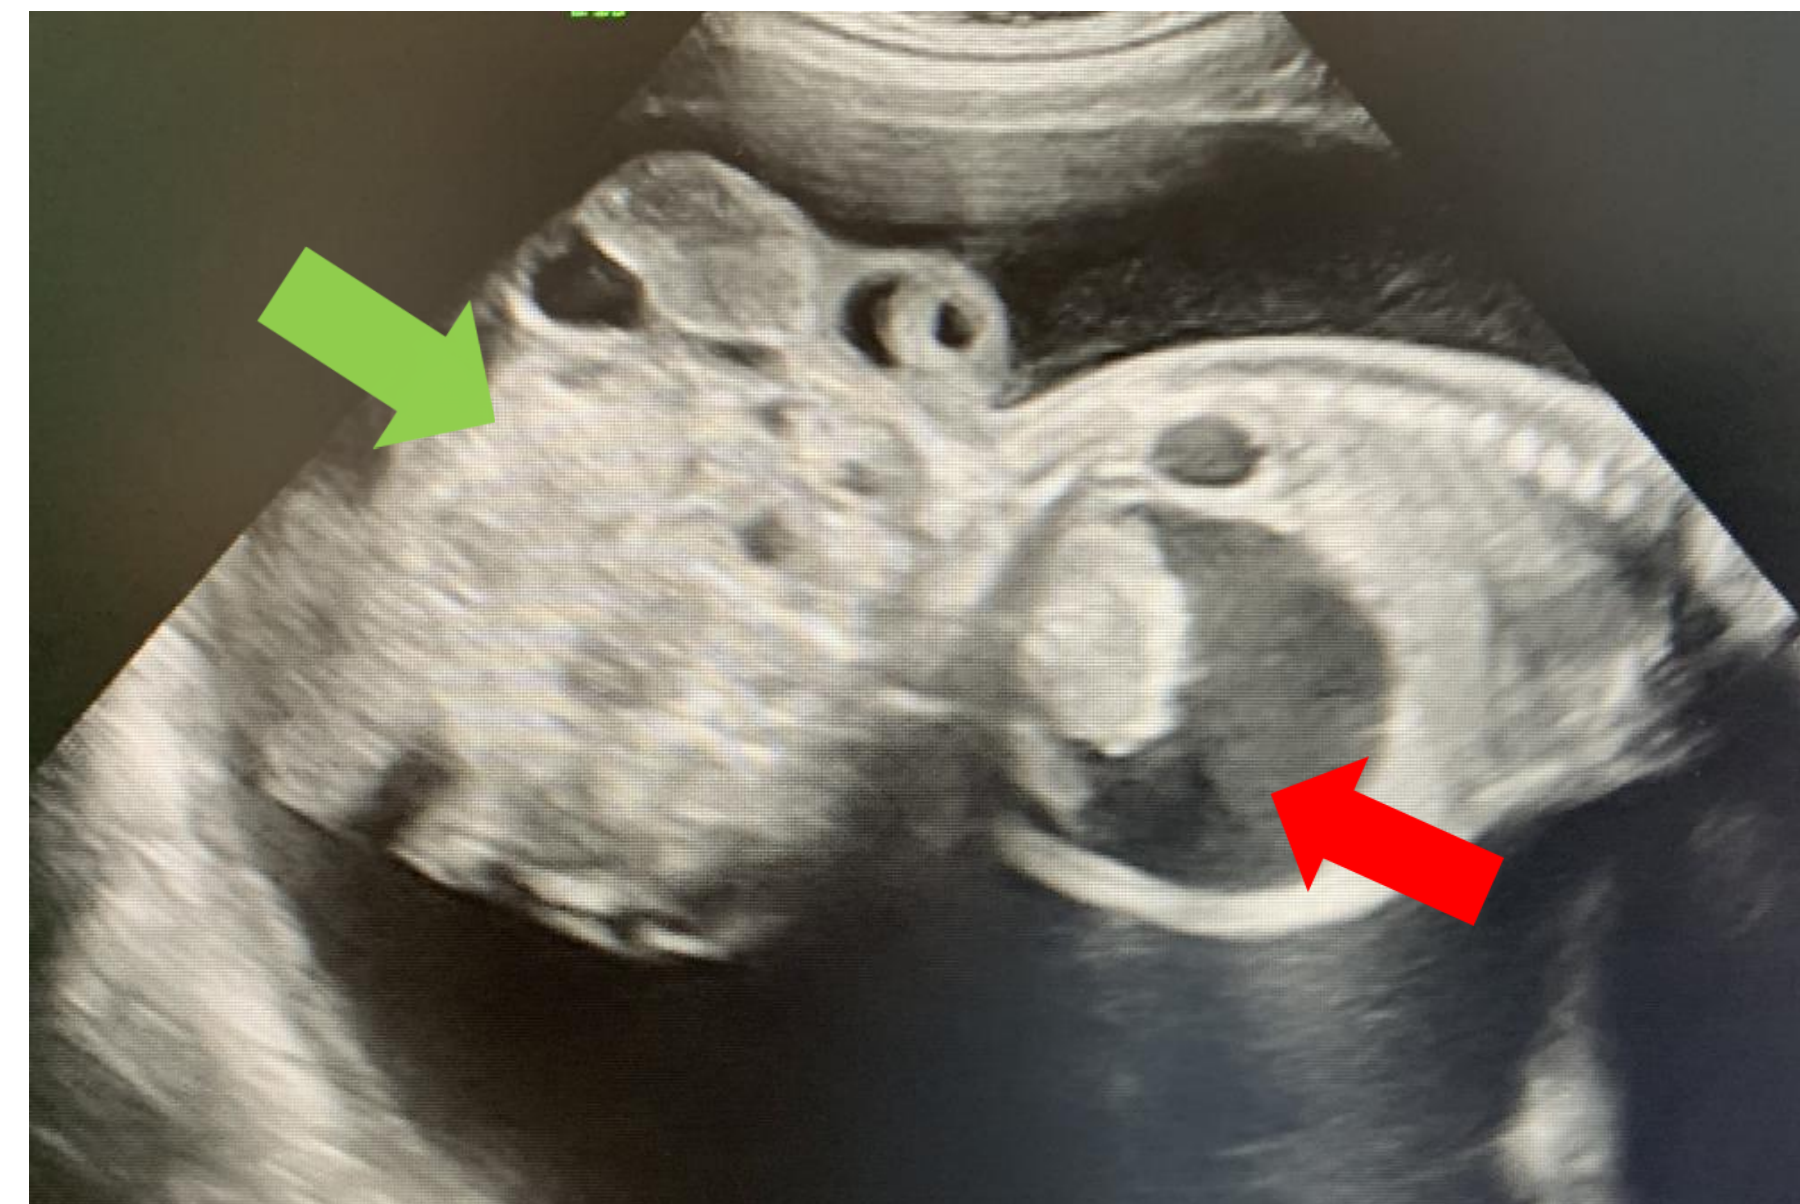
Ultrasound image: enlarging SCT (arrow), worsening abdominal ascites (arrow) and polyhydramnios
